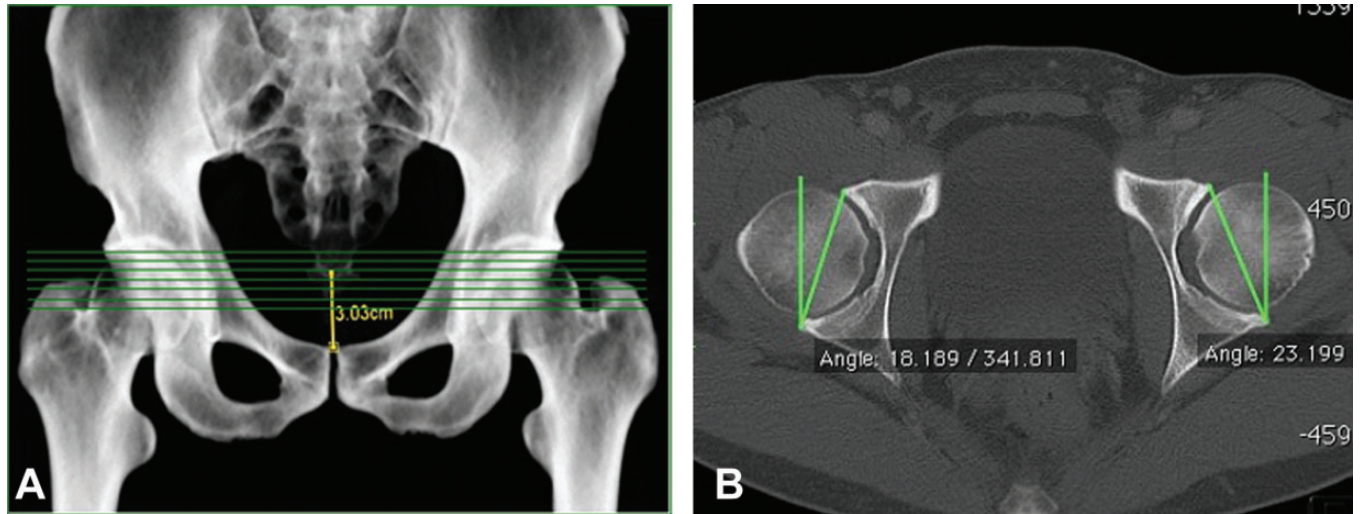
Acetabular version angle measurement. (A) The 7 levels are shown in a 3-dimensional reconstruction of a computed tomography (CT) scan. (B) The measurement is shown for level 6 in an axial CT reconstruction corrected on 3 planes.
